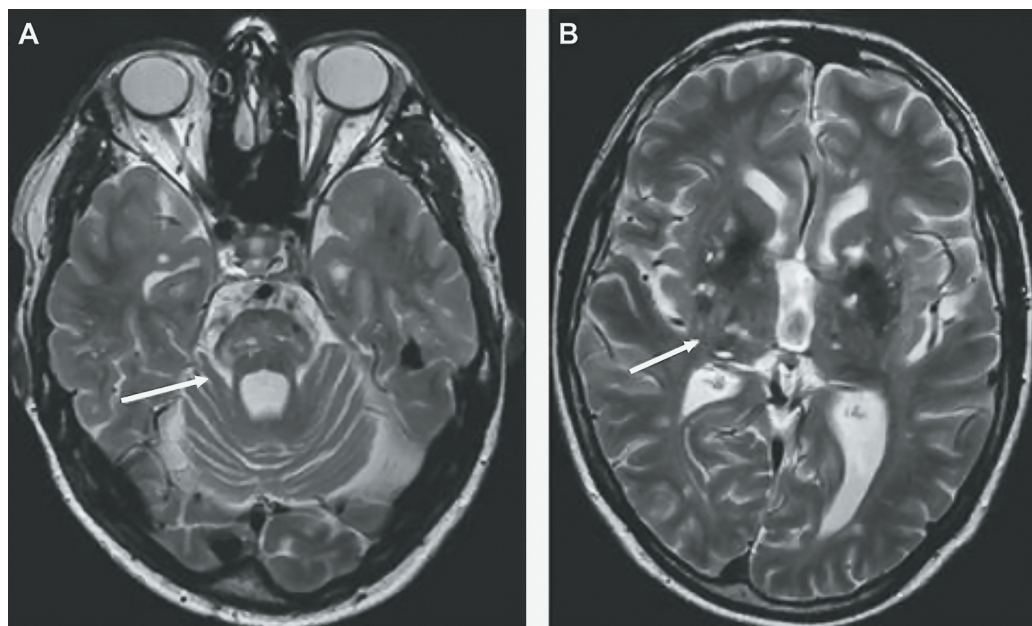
T2-weighted magnetic resonance images of a 42-year-old male with hereditary multi-infarct dementia of Swedish type. A) Arrow points indicate lesions in the pons, whereas the temporal poles show no signs of lesions. B) Multiple lesions are present in the basal ganglia and thalamus but the capsula externa is intact. (Cf. Figure 2A)
